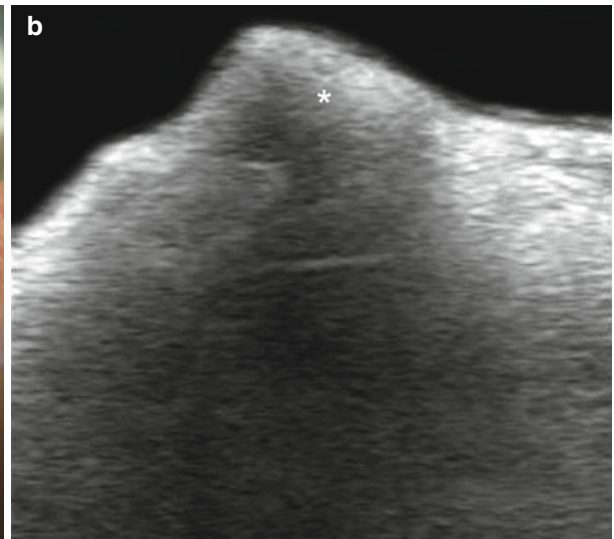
(a, b) Silicone oil. (a) Clinical image shows lumps (*arrows*) in the vestibule of the oral cavity. (b) Grey scale ultrasound image (transverse view) demonstrates hyperechoic material (*) that produces posterior reverberation artifact and a "snow storm" pattern affecting the lower lip layers (submucosal and orbicularis muscle)
